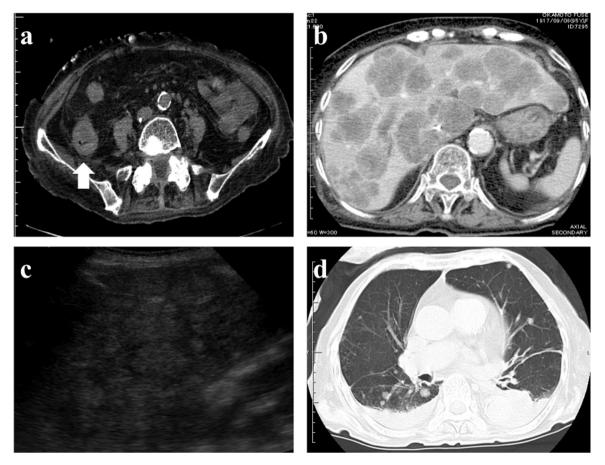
a and b: An abdominal computed tomography (CT) study showed a tumor with a diameter of 6 cm occupying the right upper abdominal quadrant together with multiple liver lesions (arrow). c: Ultrasonography showed well-defined hypoechoic liver tumors. d: Chest CT scan showed multiple lung lesions.
